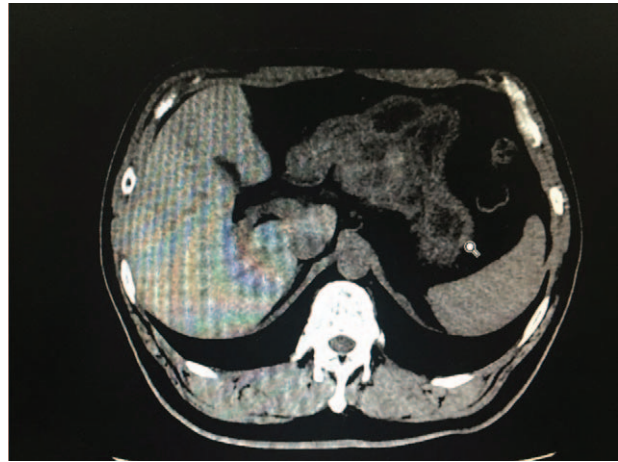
Plain CT scan of the MCN. CT=computed tomography, MCN=mucinous cystic neoplasm.
